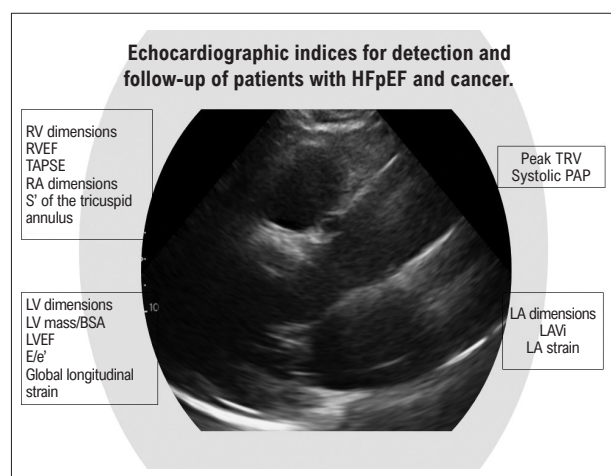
Echocardiographic indices for detection and follow-up of patients with HFpEF and cancer. BSA: body surface area; E/e': ratio of early diastolic mitral inflow velocity to early diastolic velocity of the mitral annulus; HFpEF: heart failure with preserved ejection fraction; LA: left atrium; LAVi: left atrial volume indexed by body surface area; LV: left ventricle; LVEF: left ventricular ejection fraction; PAP: pulmonary artery pressure; RA: right atrium; RV: right ventricle; RVEF: right ventricular ejection fraction; S': systolic velocity obtained by Doppler tissue imaging; TAPSE: tricuspid annular plane systolic excursion; TVR: tricuspid regurgitation velocity.
